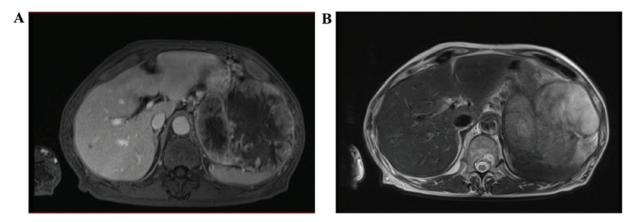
Magnetic resonance imaging revealed that the tumor exhibited low signal intensity on T1-weighted images and high signal intensity on T2-weighted images. (A) T1-weighted image, (B) T2-weighted image.
